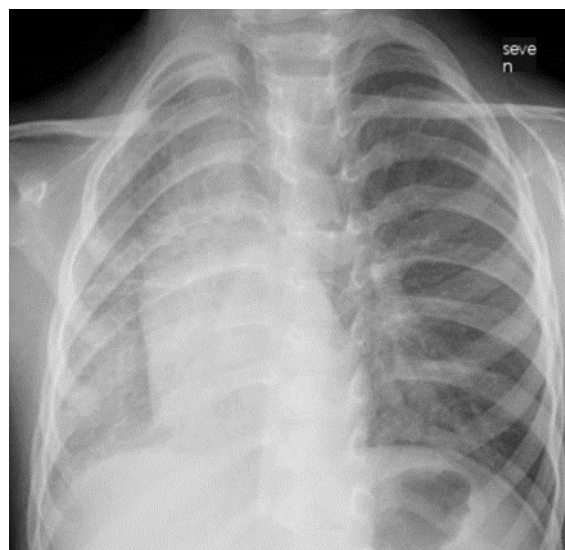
Chest X-ray. Note: The patient's right thorax was slightly smaller, the mediastinum was shifted to the right, the right lung markings were thickened, and the heart shadow was to the right.
